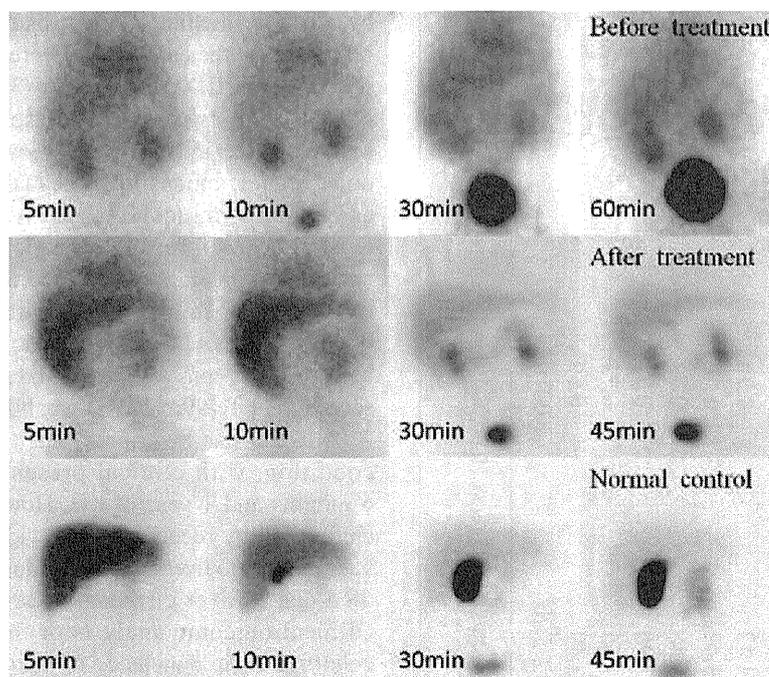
Hepatobiliary scintigraphic findings with Tc-99m-EHIDA as a radioactive tracer in a male infant (C0025) with citrin deficiency. Note the impaired hepatic uptake of the tracer and consequent failure of bile duct and bowel visualization before treatment (upper lane, at the age of 2.8 months). Hepatic uptake was improved significantly in the same children after treatment, however, delayed hepatic discharge and delayed/weak bile duct and bowel visualization (middle lane, at the age of 3.3 months) were still observed, compared with the normal control (lower lane) that demonstrated good hepatic uptake at 5 min, clear bowel visualization as well as liver parenchymatous discharge at 45 min.
